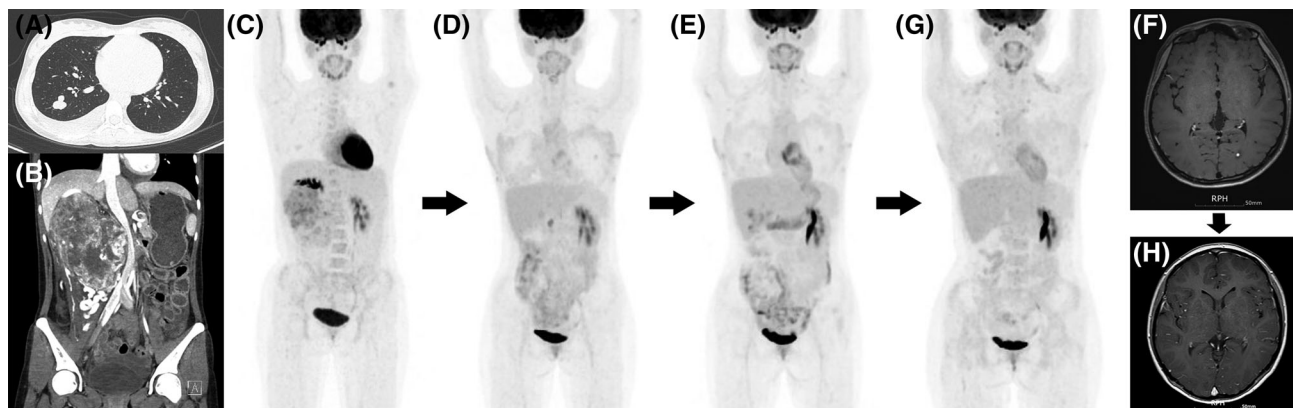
Initial computed tomography (CT) of chest (A), magnetic resonance image (MRI) of abdomen (B) and brain (F–H) and serial positron emission tomography (PET) scan of the torso (basal skull to proximal thigh) with $F-^{18}$ FDG and attenuation correction by CT in a female with alveolar soft part sarcoma (ASPS) (C–E and G). (A) Chest CT revealed well-defined variable-sized nodules, which were pathologically confirmed as pulmonary metastases of ASPS. (B) MRI of abdomen showed a huge, solid heterogeneous mass in the right infrarenal and paravertebral region, measuring $14 \times 11 \times 8$ cm with internal hemorrhage and necrosis. (C) Initial PET-CT revealed a 14 cm hypermetabolic mass at the right infrarenal area (SUVmax: 5.7) and two hypermetabolic nodules of the right lower lung (SUVmax: 1.8). (D) Follow-up PET-CT performed 1 month after the operation. It revealed a newly formed hypermetabolic lesion in the bed of the right nephrectomy, consistent with tumor recurrence. (E) Follow-up PET-CT revealed an increased extent of previous hypermetabolic mass lesions of the right nephrectomy bed and right paravertebral space. (F) MRI of brain showed new metastatic nodule in the left peritrigonal white matter. (G) Complete resolution of cancer recurrence at the right nephrectomy bed and right paravertebral space, and no abnormal FDG uptake in the lungs. (H) Follow-up MRI of brain showed no nodular enhancing lesion in the left peritrigonal white matter
